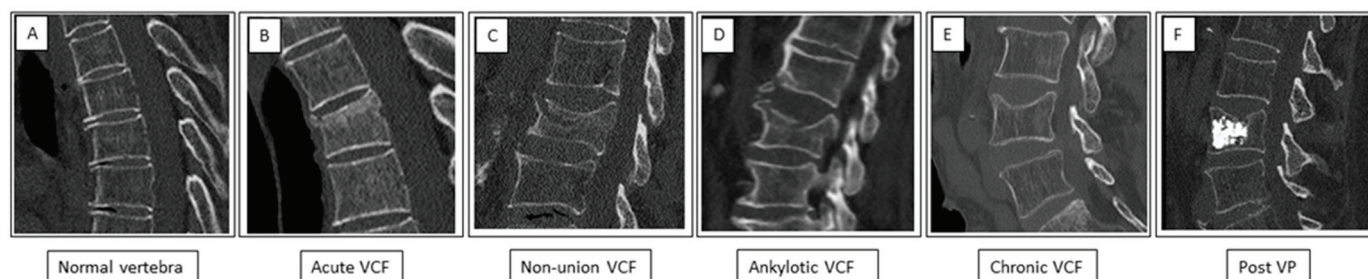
Patterns of vertebrae appearance on sagittal spine CT. (A) Normal vertebra—retained height and continuous cortex. (B) Acute VCF showing a “step defect” in the anterior border and a “zone of impaction” caused by impaction of the trabeculae. (C) Non-union fracture—a non-healed fracture with an intervertebral cleft (white arrow). (D) Ankylotic fracture—a transverse fracture below an ankylotic spine segment. (E) Chronic fracture showing loss of height and smooth cortical borders. (F) State after percutaneous vertebroplasty (Post VP)—chronic fracture with loss of height and hyperdense cement in the vertebral body.
